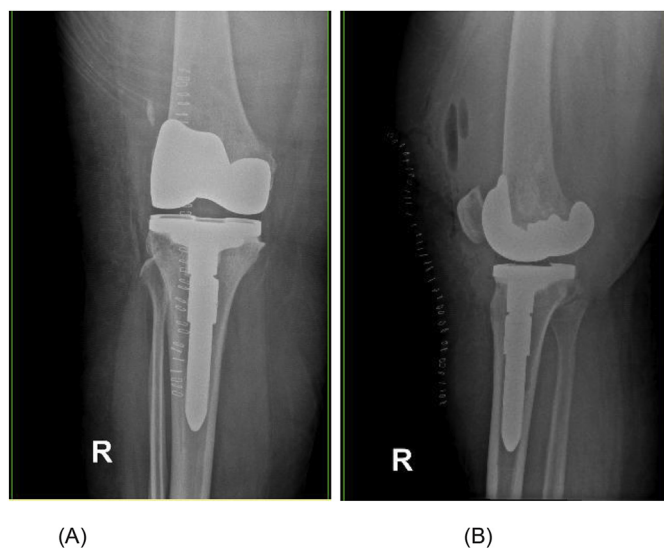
Standing anteroposterior (A) and lateral (B) radiographs 2 days following the right primary total knee arthroplasty.
